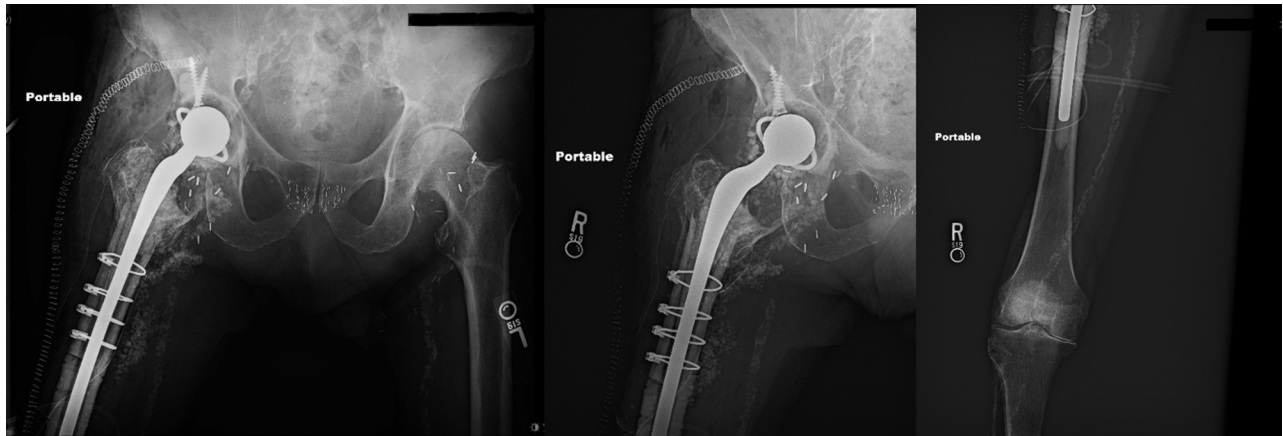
Immediate postoperative radiographs showing excellent position of the antibiotic spacer and anatomic alignment of the osteotomy.
